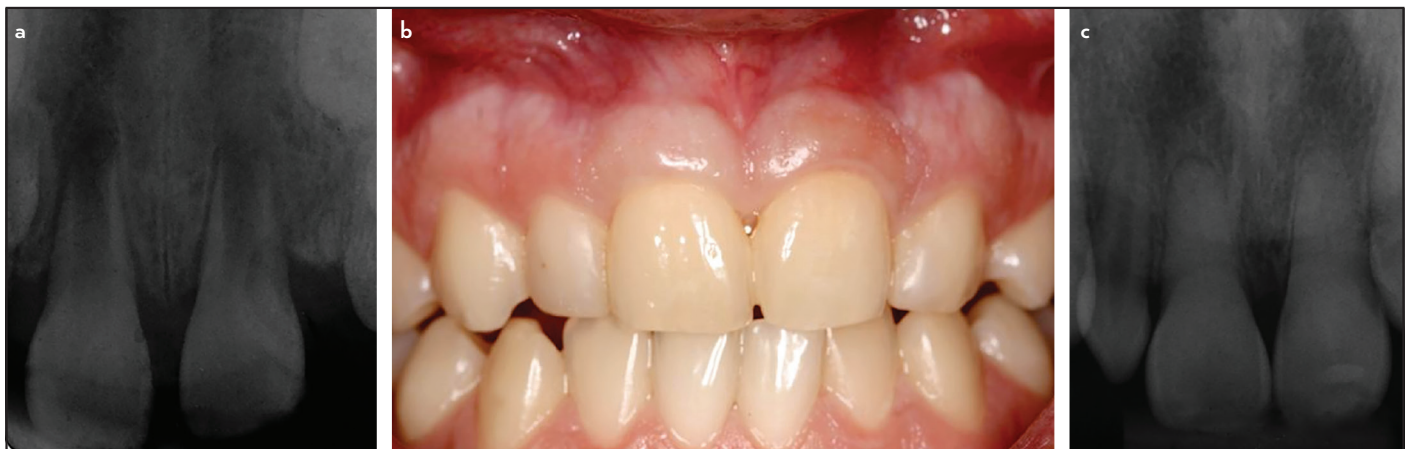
a-c. (a) Initial radiographic exam after dental replantation, (b) clinical aspect of maxillary central incisors at five years post-trauma, (c) radiography evaluation at 60 months
